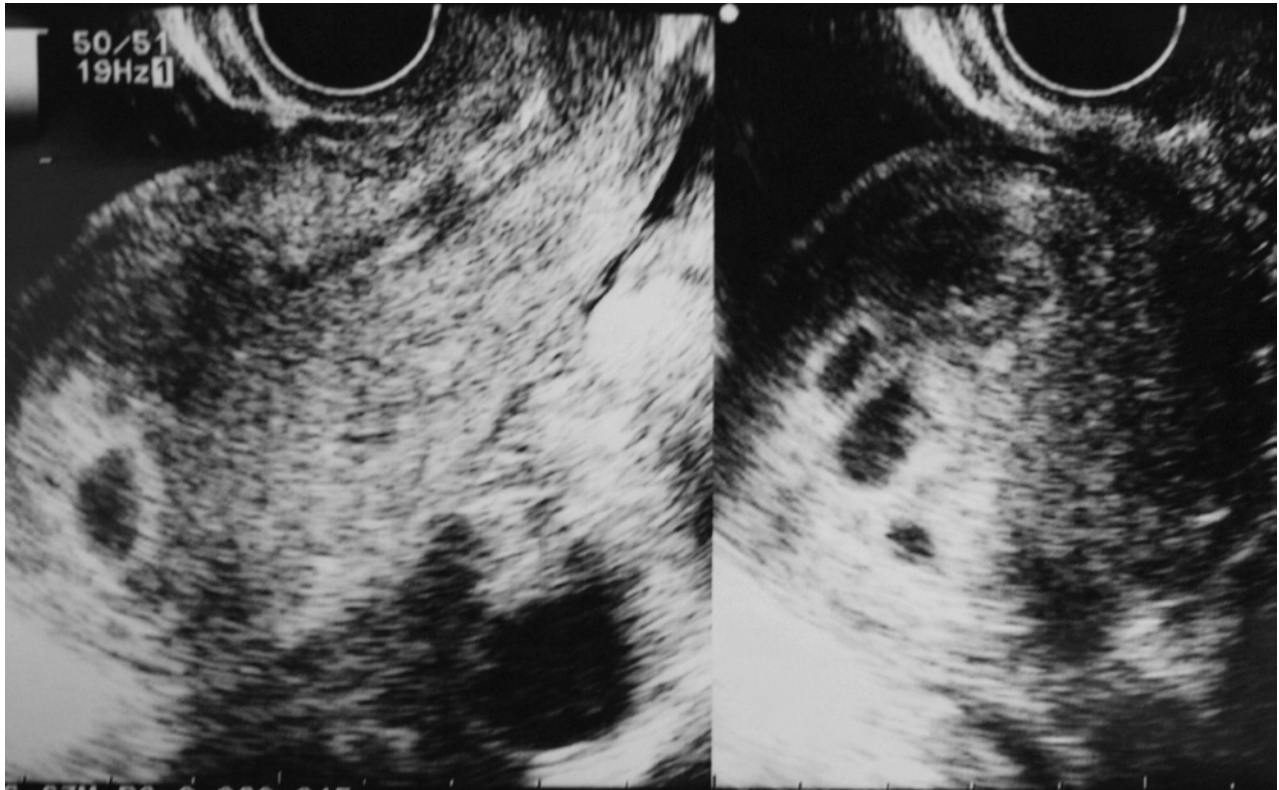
Ultrasound image showing four gestational sacs in the uterus.
